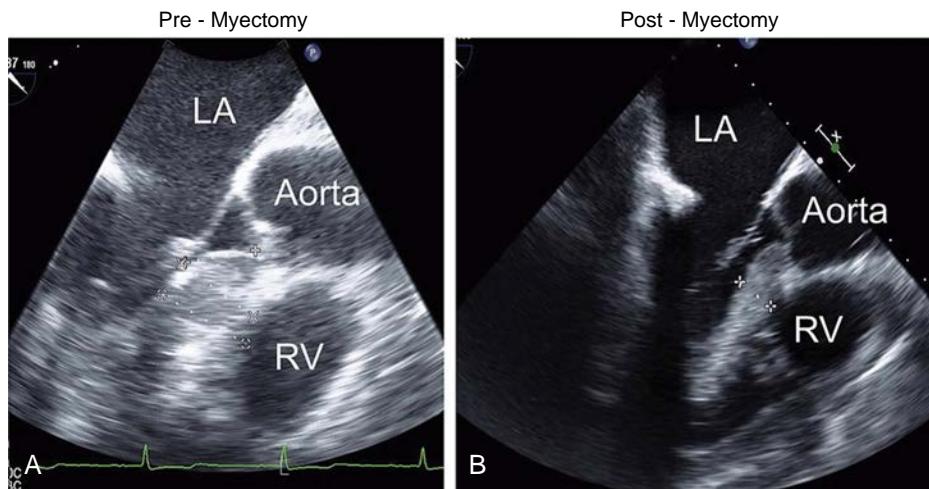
Transesophageal echocardiography of septal measurements before myectomy (A) (thickness, 2.9 cm) and after myectomy (B) (thickness, 1.5 cm). LA, Left atrium; RV, right ventricle. (From Nagweh SF, Bierig SM, Budoff MJ, et al. American Society of Echocardiography clinical recommendations for multimodality cardiovascular imaging of patients with hypertrophic cardiomyopathy: endorsed by the American Society of Nuclear Cardiology, Society for Cardiovascular Magnetic Resonance, and Society of Cardiovascular Computed Tomography. *J Am Soc Echocardiogr*. 2011;24:473–498.)
